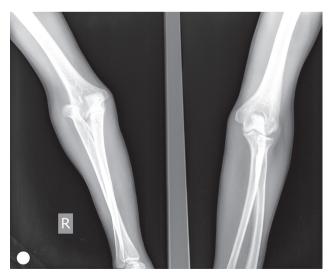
X-ray of the patient showing radial head dislocation.
